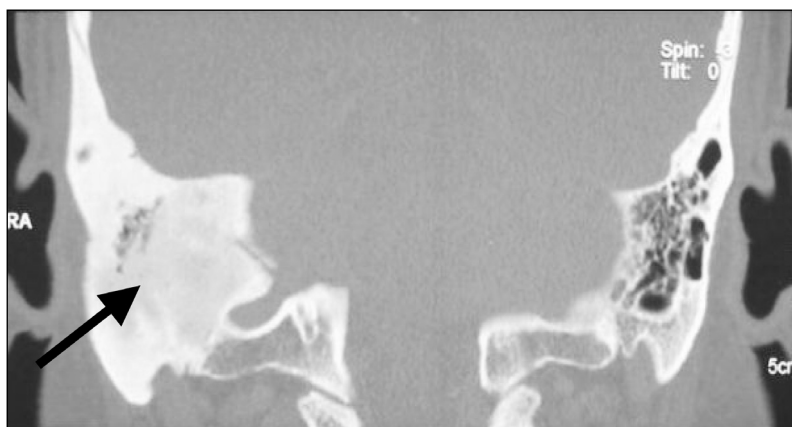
Coronal High-resolution CT which also demonstrates the bony expansion of the right temporal bone with lytic changes within the mastoid air-cells as shown by the arrow.
